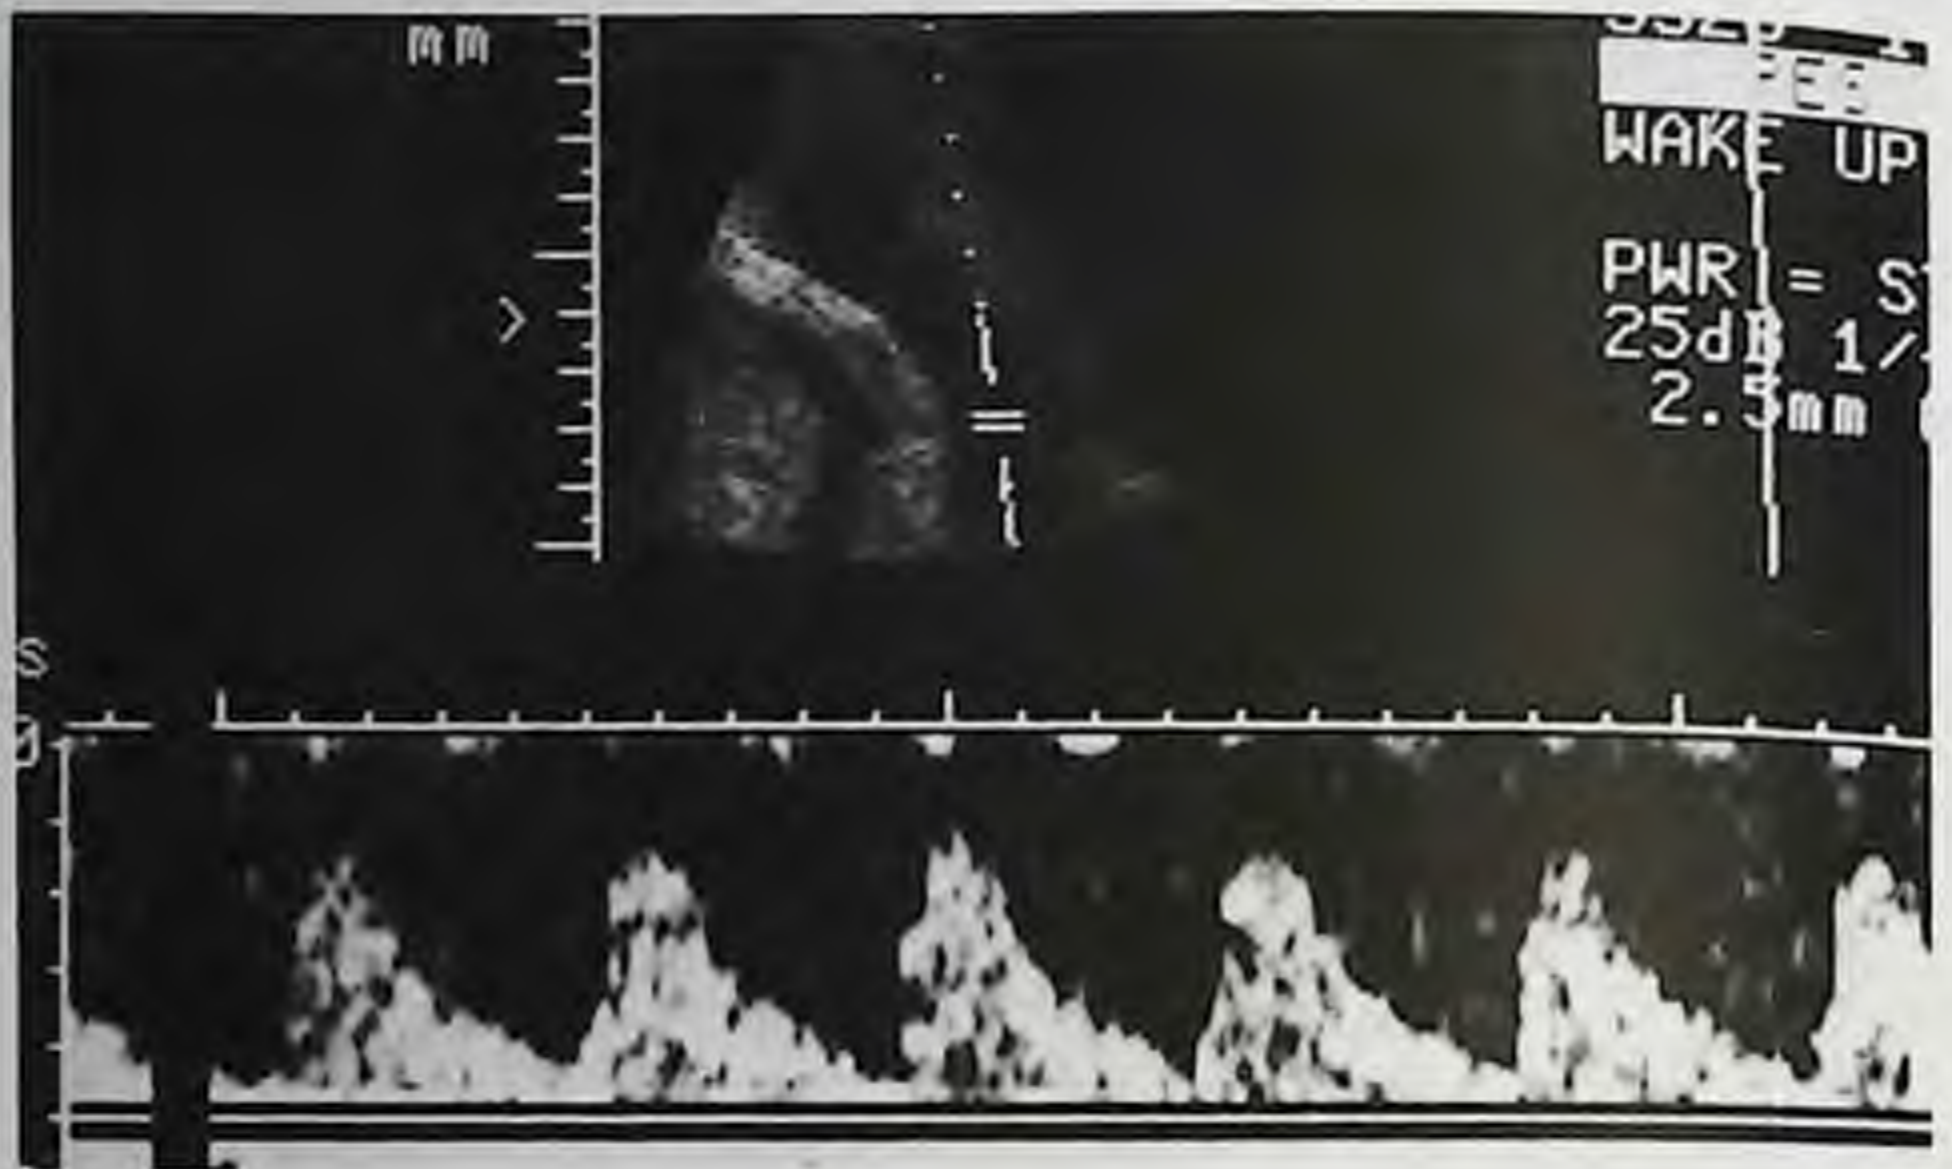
Doppler ultrasound pattern with severe anemia. The fetus had ascites and was moribund, with emergency delivery at 34 weeks' gestation. The fetus had a hemoglobin of 14 gm per liter and died neonatally. Doppler waveform shows elevated S/D ratio.
